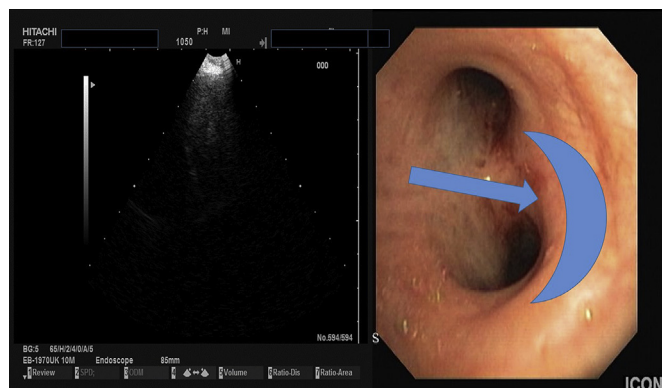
Endoscopy with convex probe endobronchial ultrasound (EBUS) blue arrow indicating the block of lymph-nodes.
